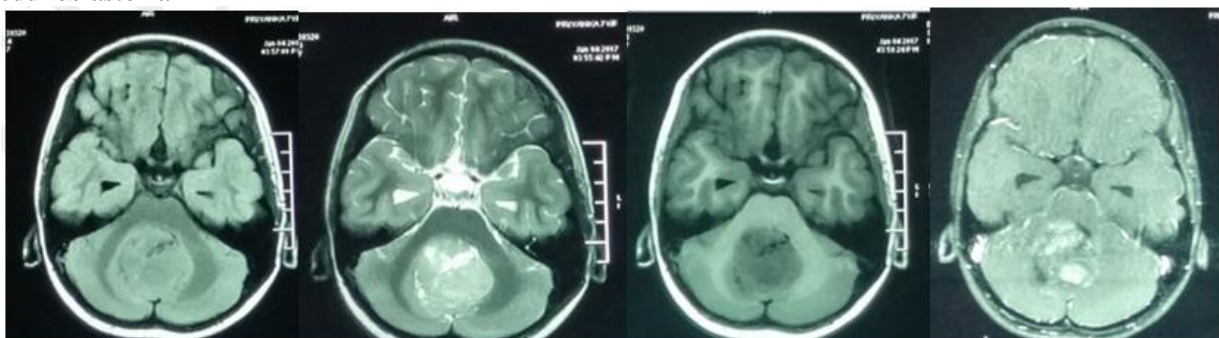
a) Plain and Contrast MRI Brain showing mid-cerebellar mass causing obstructive hydrocephalus.
